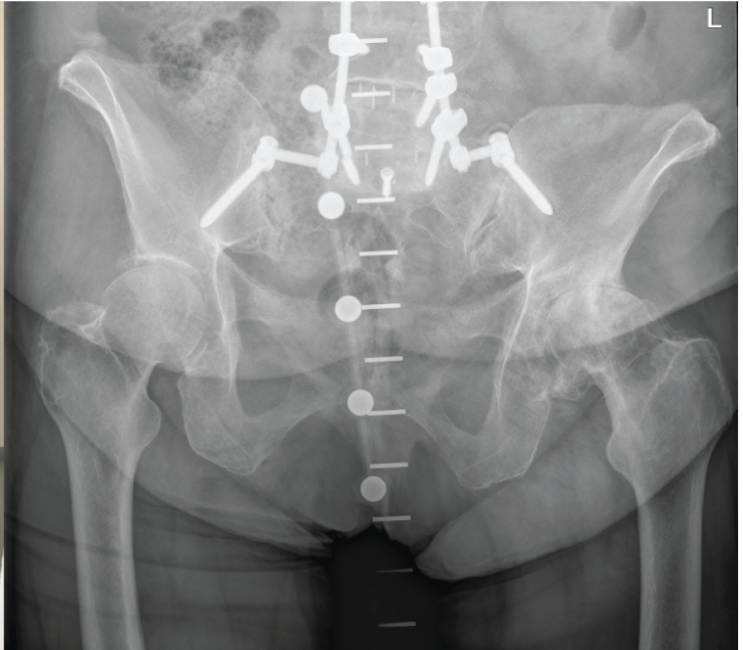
Photographs and radiographs of a patient with previous spinopelvic fusion.
